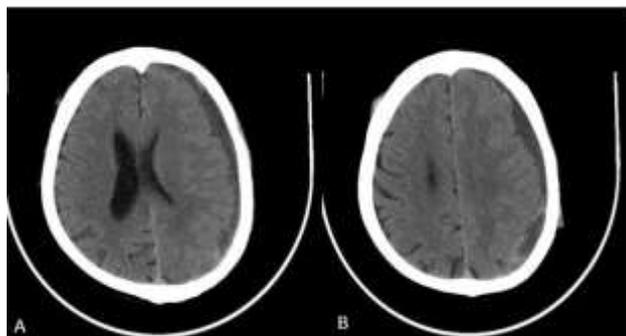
(A and B): Plain CT scan showing hypodense chronic subdural hematoma in left fronto-parietal region causing mild ventricular mass effect.
